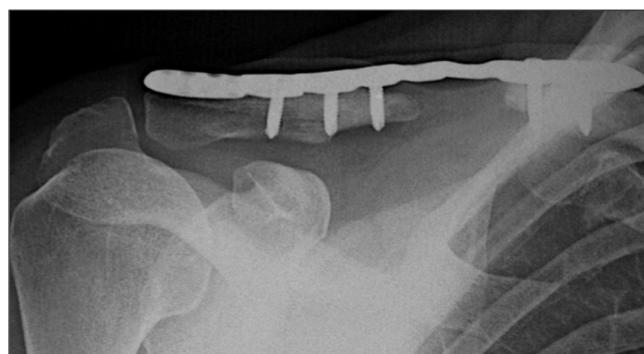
Final X-ray of the first patient.
